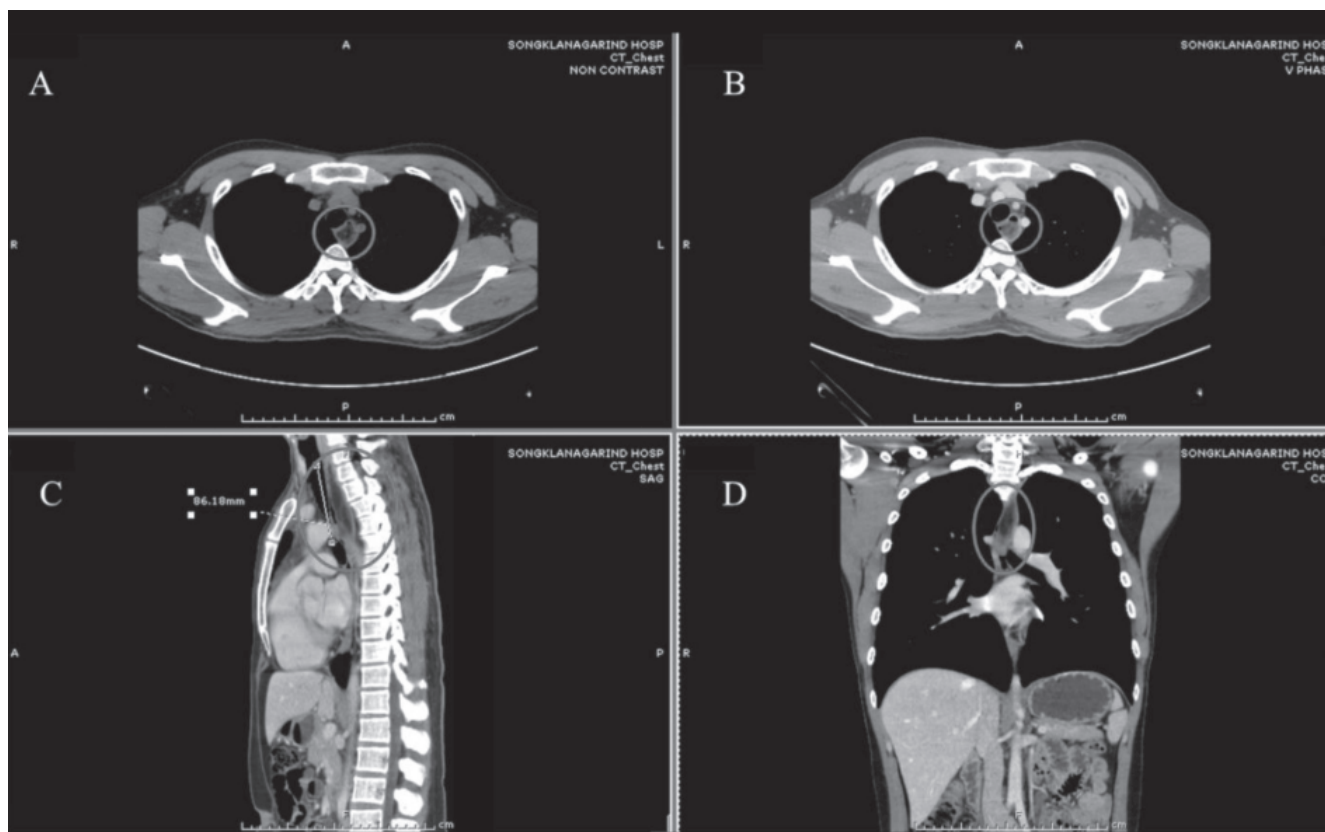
Chest CT scan demonstrated well-defined, tubular shaped lesion at the proximal esophageal lumen.
